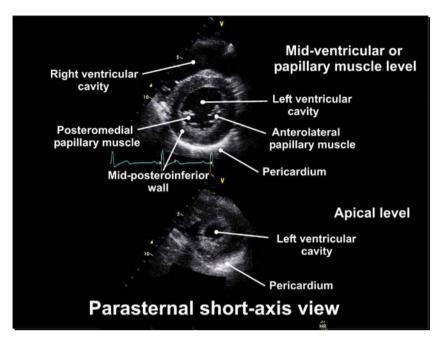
Annotated parasternal short axis (PSAX) view: midleft ventricle level and apex (PSAX). (See companion DVD.)
